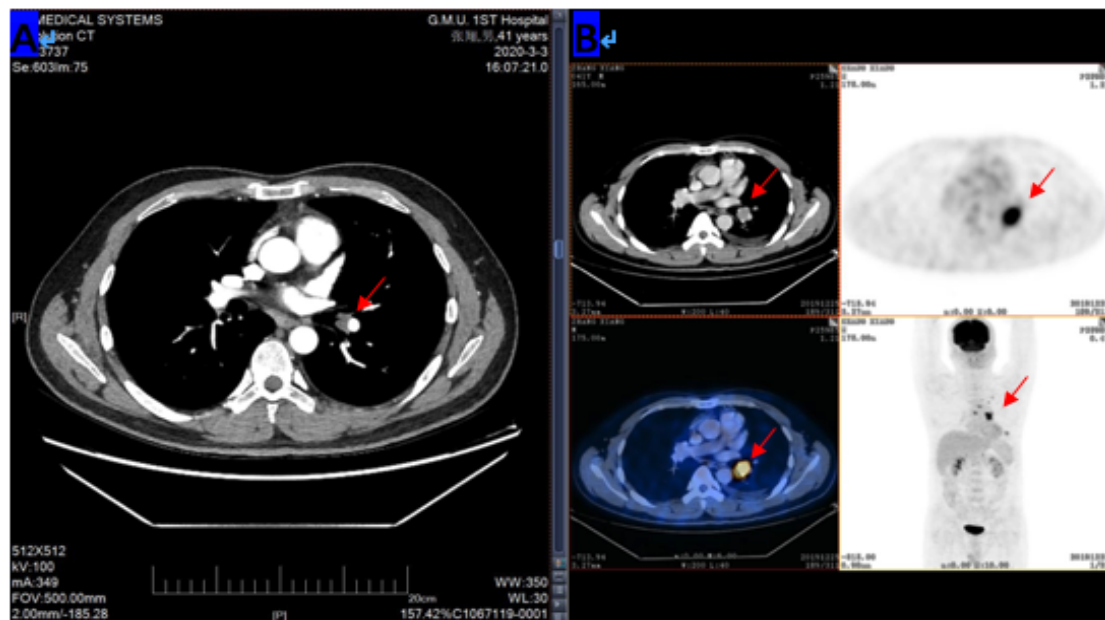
(A) Chest CT image demonstrating a high-density mass (red arrow) located the inferior tongue segment of the upper lobe of the left lung. (B) Whole-body ^{18}F -FDG PET image showing increased FDG uptake in the mass (red arrow).
